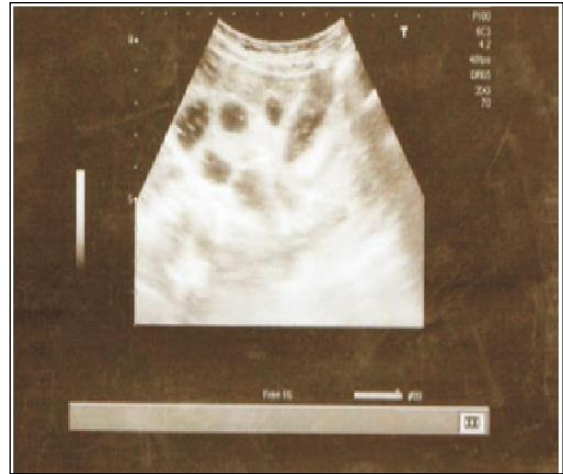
Ultrasound demonstration of the honeycomb sign of reduction of intussusception.
